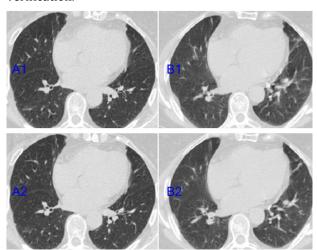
Chest computed tomography (CT) scan of a 76-year-old woman from Wuhan. Figure (A1-2) shows the first chest CT scan 1 day after onset; there are multiple fiber strip microcosms and small patchy shadows in both lungs. Figure (B1-2) shows the re-examination scan 2 days later; there are increased patchy shadows in the middle lobe of the right lung and increased GGOs in the lingual lobe of the left lung. The patient had positive throat swab testing results and was confirmed to have novel coronavirus pneumonia.
